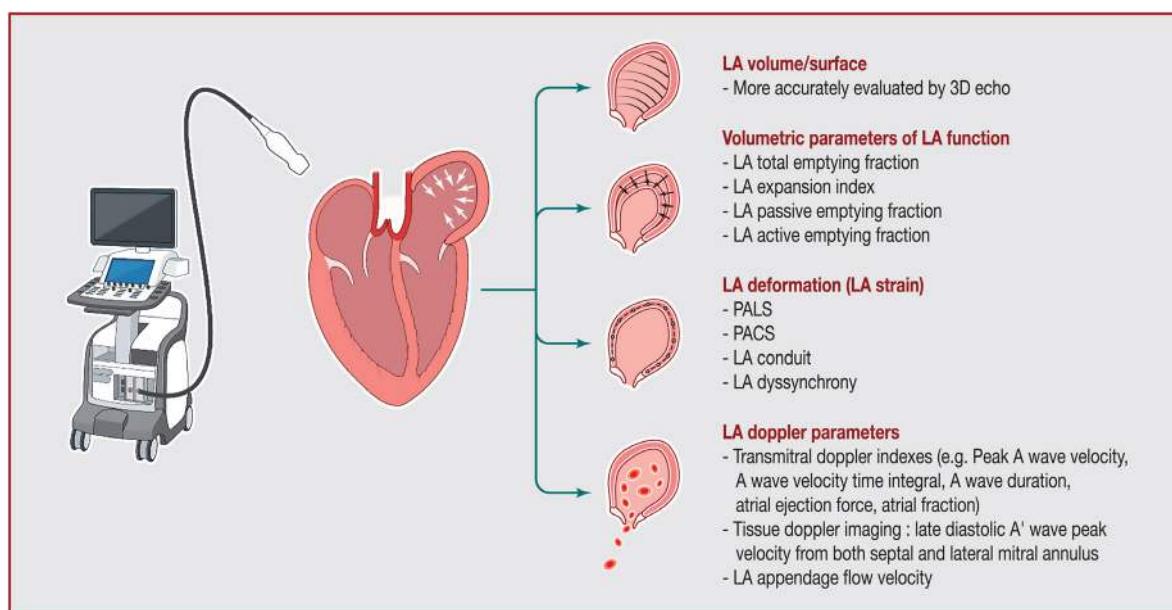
Evaluation of left atrial cardiomyopathy using echocardiography. 3D: three-dimensional; LA: left atrium; PALS: peak atrial longitudinal strain; PACS: peak atrial contraction strain.
